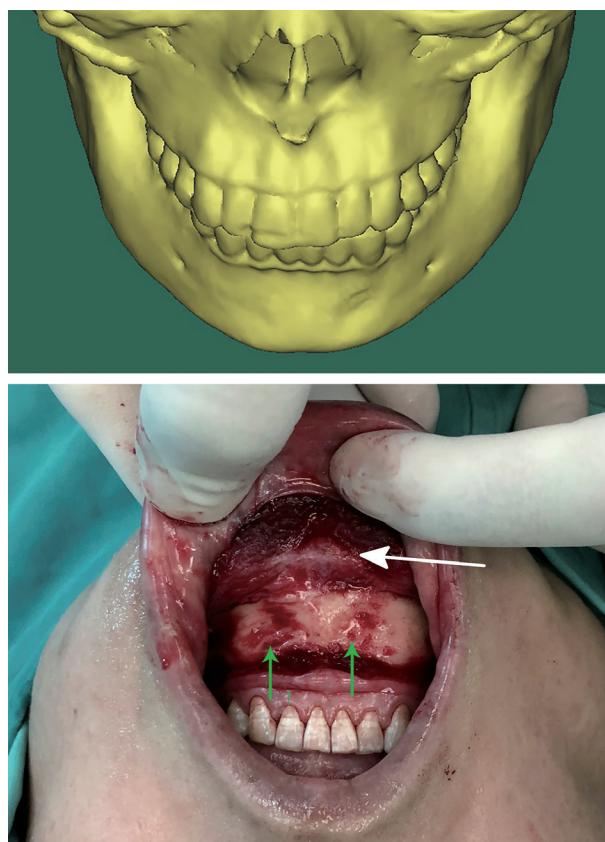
Additional case 1. (Above) Three-dimensional reconstruction of the computed tomographic scans from a 27-year-old woman. She had injection of hyaluronic acid two times (Restylane). The injection volumes were 1.5 and 0.6 ml, and the injection interval was longer than 6 months. Bony resorption could be found in bilateral incisive fossa. (Below) Intraoperative photograph of the same patient. Green arrows indicate the bone loss, and white arrow indicates the remaining hyaluronic acid.
